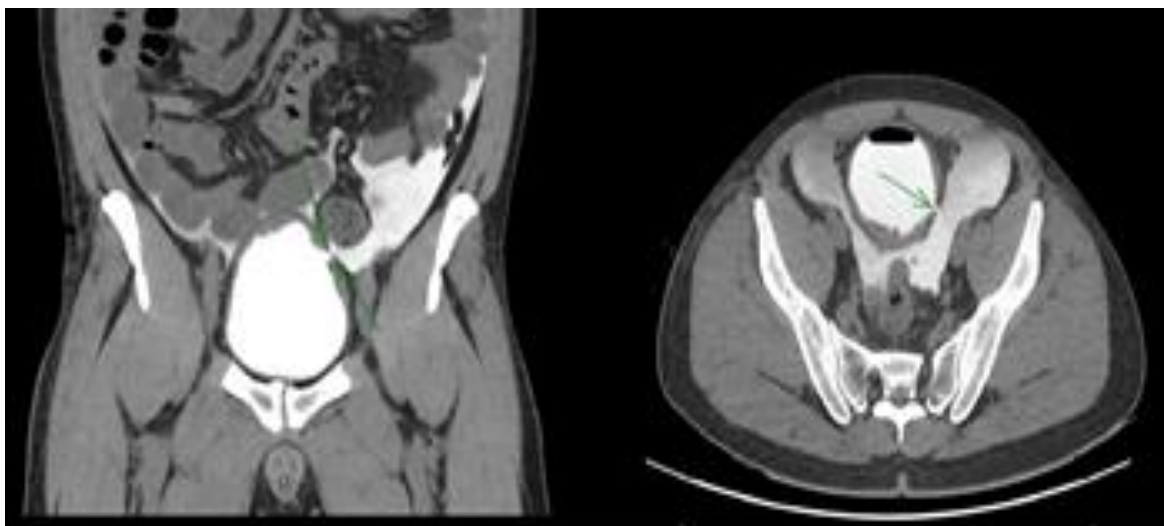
CT cystography demonstrated a tear in the dome of the bladder, through which contrast material leaks into the peritoneal cavity.
